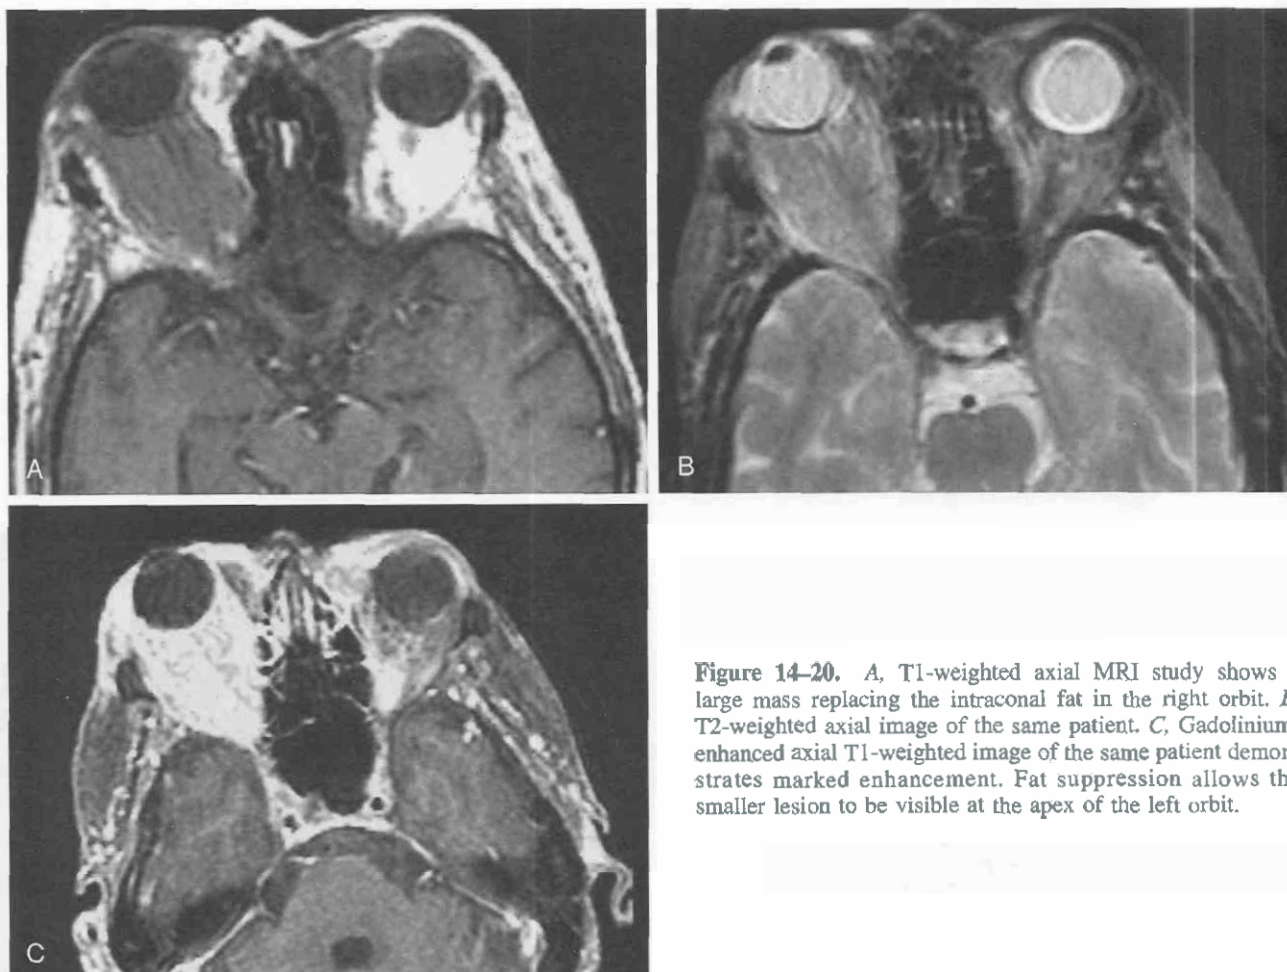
A, T1-weighted axial MRI study shows a large mass replacing the intraconal fat in the right orbit. B, T2-weighted axial image of the same patient. C, Gadolinium-enhanced axial T1-weighted image of the same patient demonstrates marked enhancement. Fat suppression allows the smaller lesion to be visible at the apex of the left orbit.
